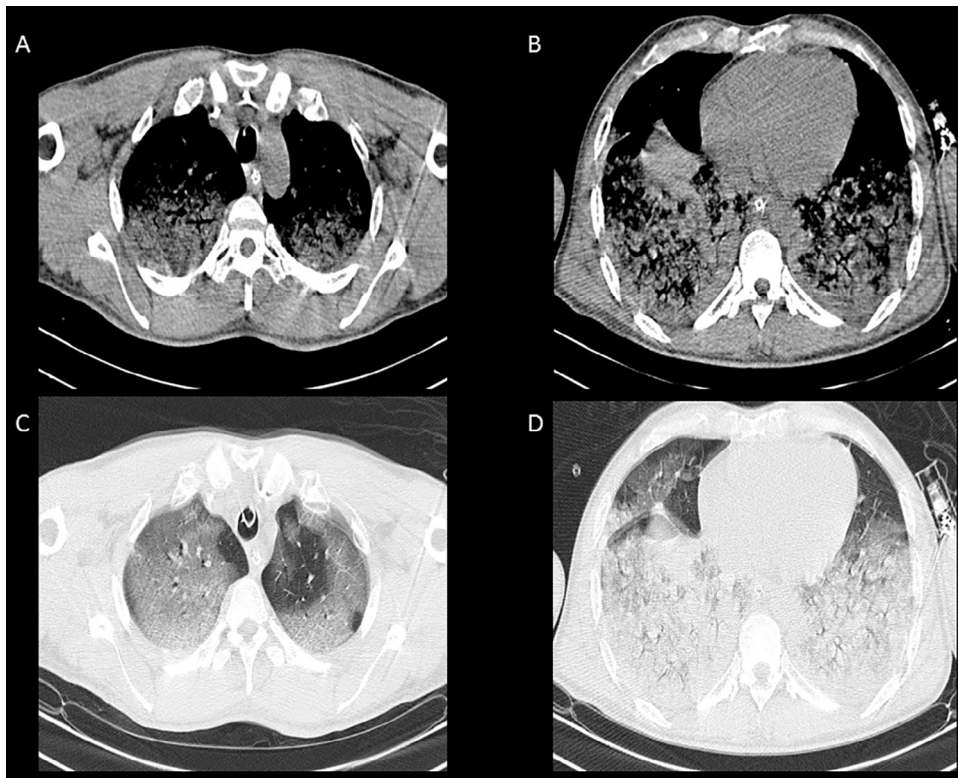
Computed tomography (CT) of the thorax. Bilateral posterior and inferior lobular involvement at the alveolar level; images compatible with ground glass opacities and air bronchogram. A and B) Axial plane CT without contrast, mediastinal window, areas of alveolar involvement at the posterior and inferior lobules in bilateral hemithorax. B) Regions of consolidation associated with air bronchogram. C and D) Axial plane CT of the thorax without contrast, lung window. C) Pulmonary apical regions with ground glass opacities identified bilaterally. D) Lower level axial planes, where ground glass opacities can also be identified, coalescing into regions of consolidation associated with air bronchogram.
